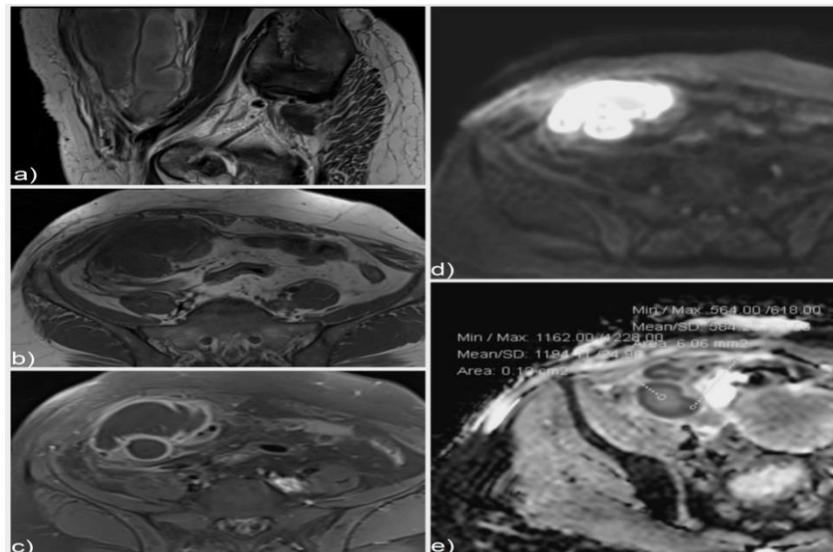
MRI pelvis showing tubo-ovarian abscess of right adnexa; a) On sagittal T2W images a large retort shaped lesion seen in right adnexa showing peripheral hyperintense signal and central low signal intensity content (necrosis); b) On axial T1W image this lesion is appearing hypointense; c) On T1FSC+ image this lesions shows peripheral rim enhancement. d) & e) are b value and ADC images of diffusion weighted imaging, where the necrotic components of the lesion are showing diffusion restriction, with corresponding low ADC value of $0.58 \times 10^{-3} \text{mm}^2/\text{s}$.
